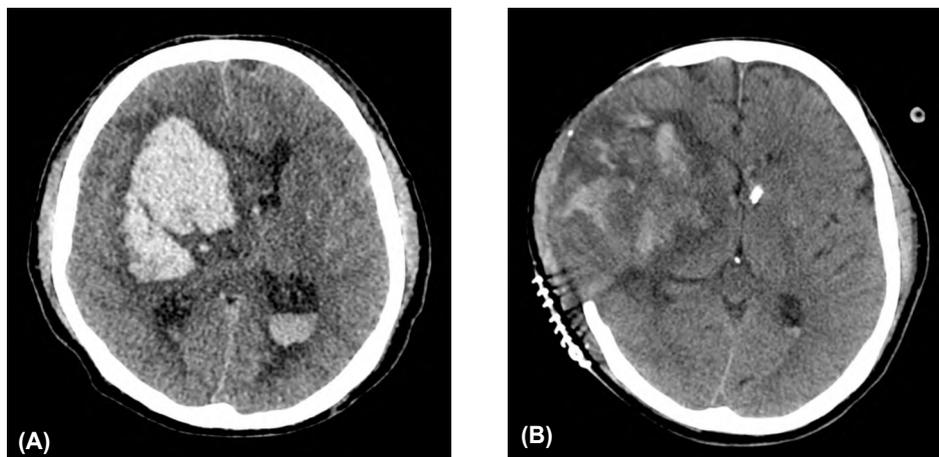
(A): Pre-operative Axial CT Scan showing traumatic hemorrhagic brain injury with marked midline shift. (B): Axial CT scan of the same case after decompressive hemicraniectomy.
